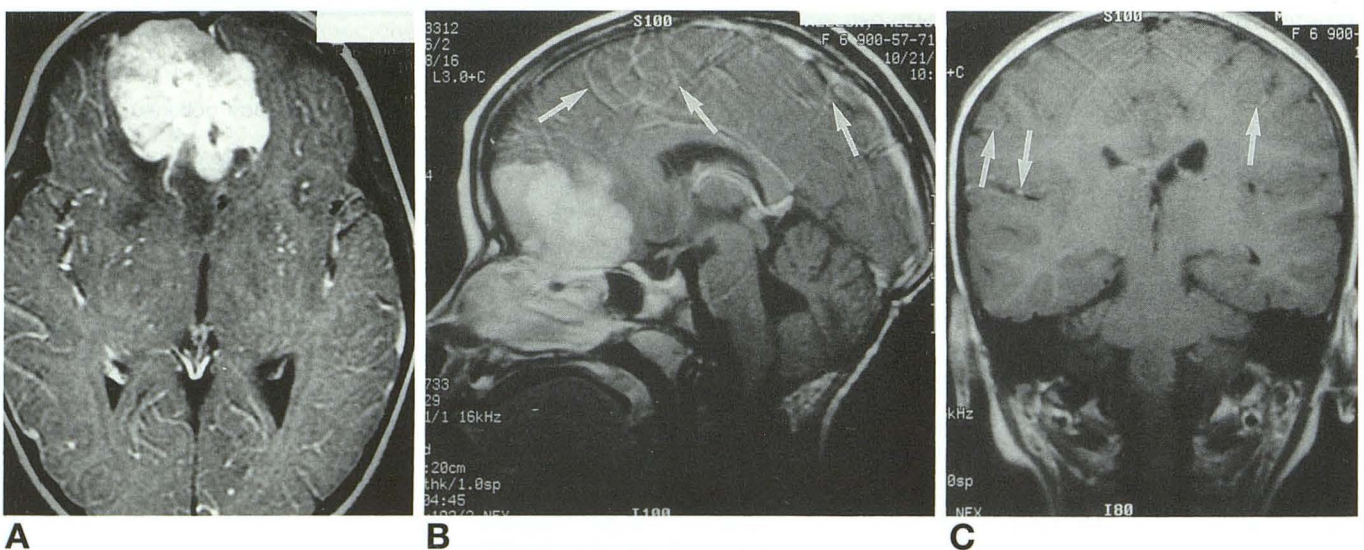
MR image of a 6-year-old girl obtained 2.3 years after surgery.
